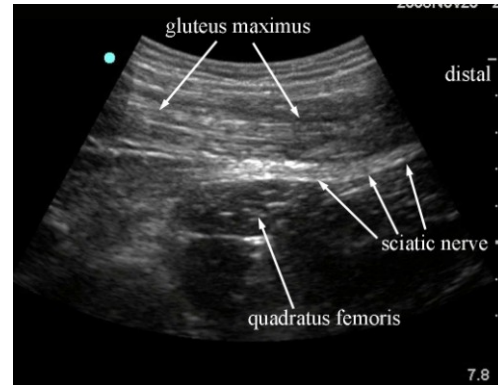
sonogram of long axis view of the sciatic nerve passing posterior to quadratus femoris.
